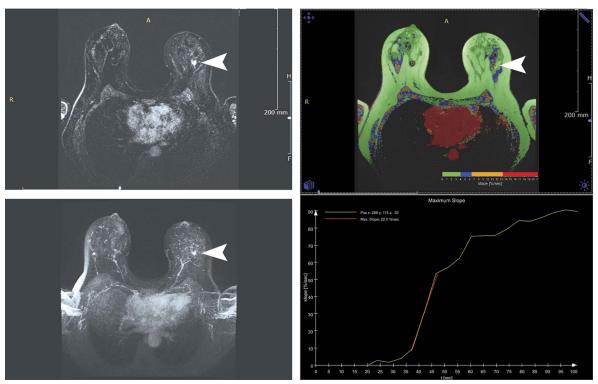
Screenshot of an ultrafast breast MRI hanging protocol. The left upper screen shows the subtraction image of the last acquisition. The left lower screen shows a maximum intensity projection of the same time point. Using the arrow keys toggling through the different time points is possible to determine TTE. In the right upper screen, MS is provided as a color-coded overlay on top of the native T1-weighted acquisition (colors correspond to the cutoffs presented in Mann et al¹¹). The right lower screen shows the actual relative enhancement versus time curve during the wash-in of contrast at the position of the cursor, with the maximum slope presented as a red line. At the arrowheads, an 11-mm invasive lobular carcinoma is depicted. Morphology, the type 3 wash-in curve, and a maximum slope of 22.0%/s allow classification of this lesion as BI-RADS 4. In addition, TTE was 8.6 seconds (not shown), further pointing in the direction of the malignant nature of this lesion.
